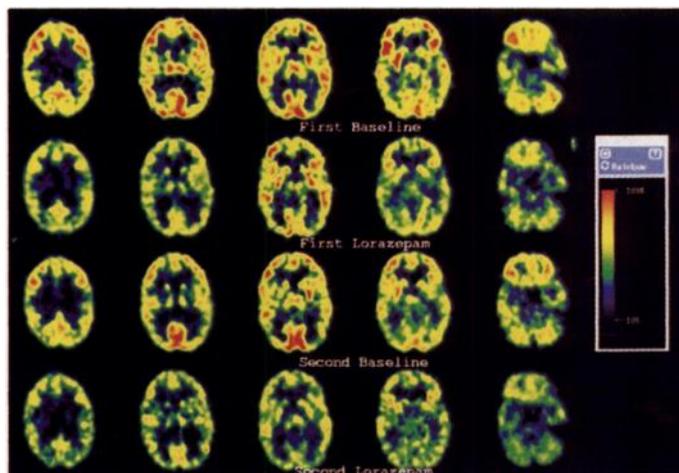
FDG-PET images of normal subject for study 1 with placebo (baseline 1), study 1 with lorazepam, study 2 with placebo (baseline 2) and study 2 with lorazepam.
